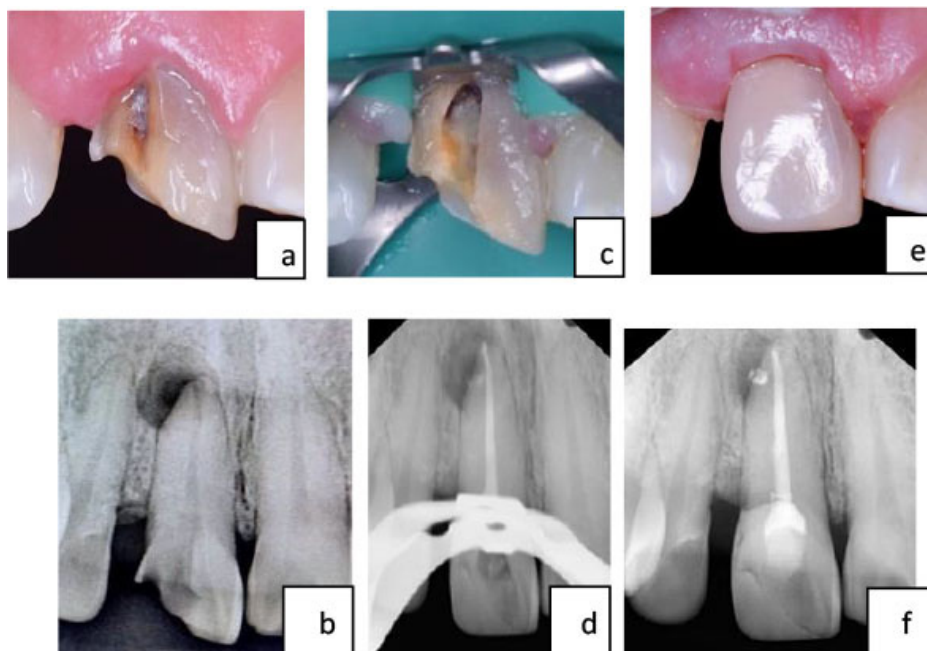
(a) and (c) pre-operative clinical image of the right maxillary first incisor; (b) pre-operative periapical radiograph showing a well-demarcated radiolucent lesion of endodontic origin at the apex; (d) post-operative periapical radiograph after obturation; (e) Post-operative clinical image of the right maxillary first incisor; (f) Post-operative periapical radiograph at 4 months of evaluation.
